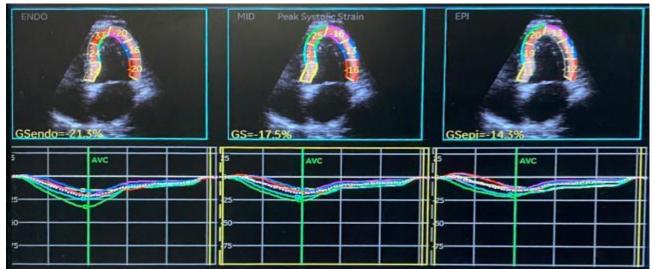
2D-STE measurement of global LSS in apical 4-chamber view in a hypertensive case with no strain, the quantitative strain measurements of the endocardium GSendo (-21.3), middle GSmid (-17.5), and epicardium GSepi (-14.3).
